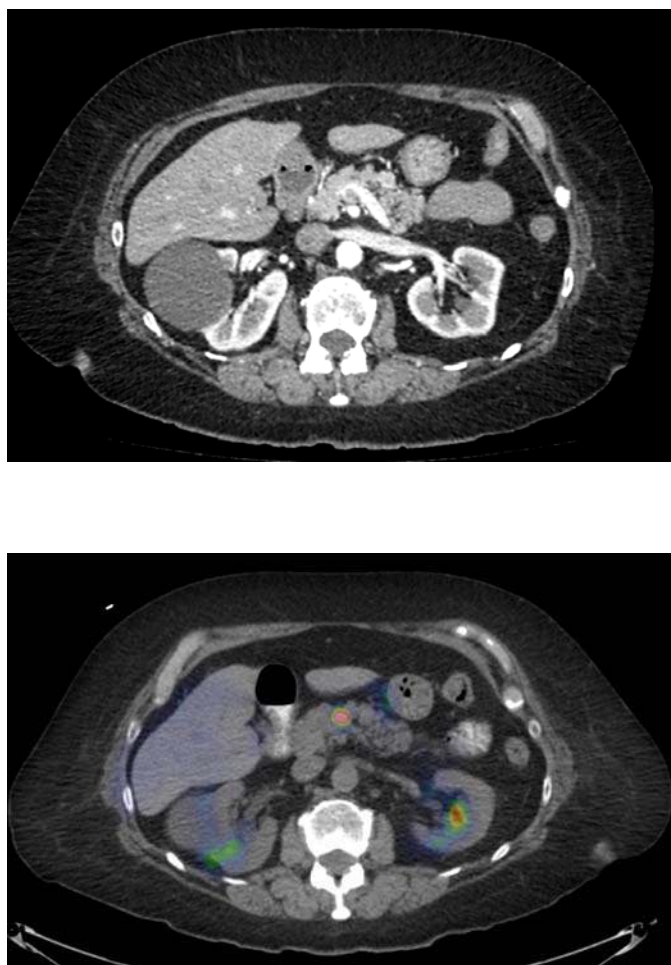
$^{68}\text{Ga}$ -DOTATOC-PET/CT A. Transverse i.v. contrast-enhanced CT in the arterial phase showing a hypervascular pancreatic NET in the ventral aspect of the pancreatic body. B.  $^{68}\text{Ga}$ -DOTATOC-PET/CT fusion image showing a high tracer uptake in the tumor.
